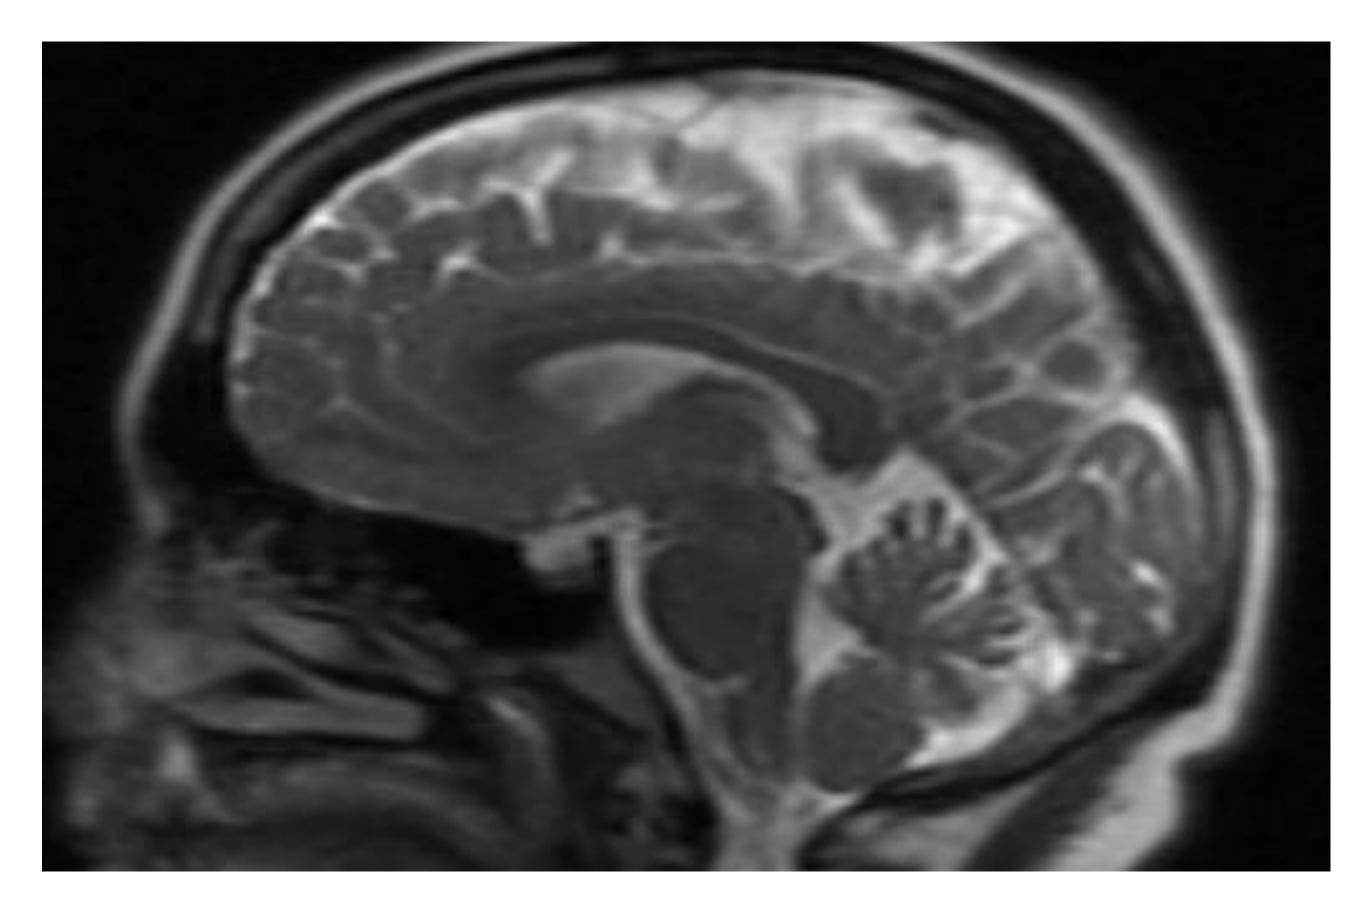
Previous MRI without Empty Sella Diagnosis
